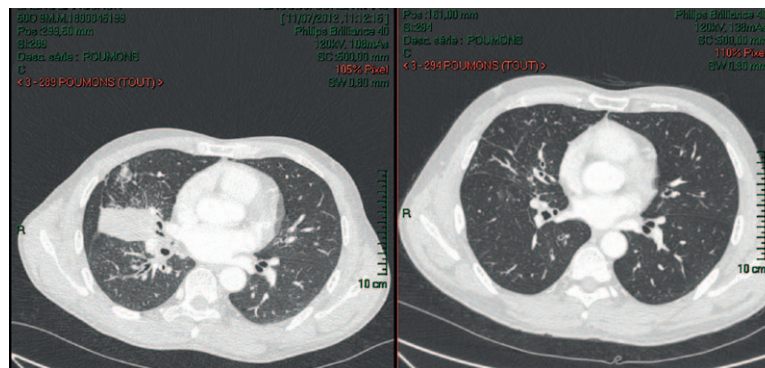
Computed tomography scan of chest of patient 1 (left) before treatment and (right) after 3 months of gefitinib treatment.
